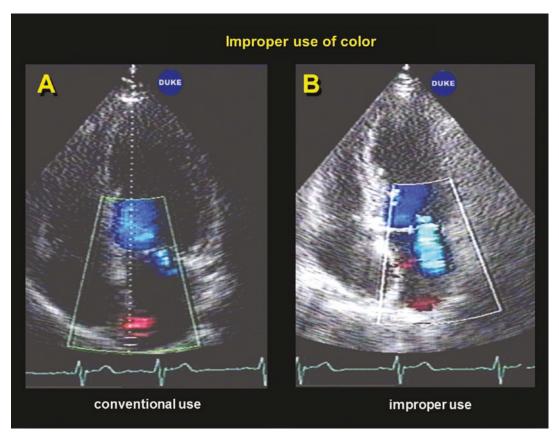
Apical four chamber views from the same volunteer showing that improper use of the color flow controls may artifactually increase the size of a regurgitant jet
